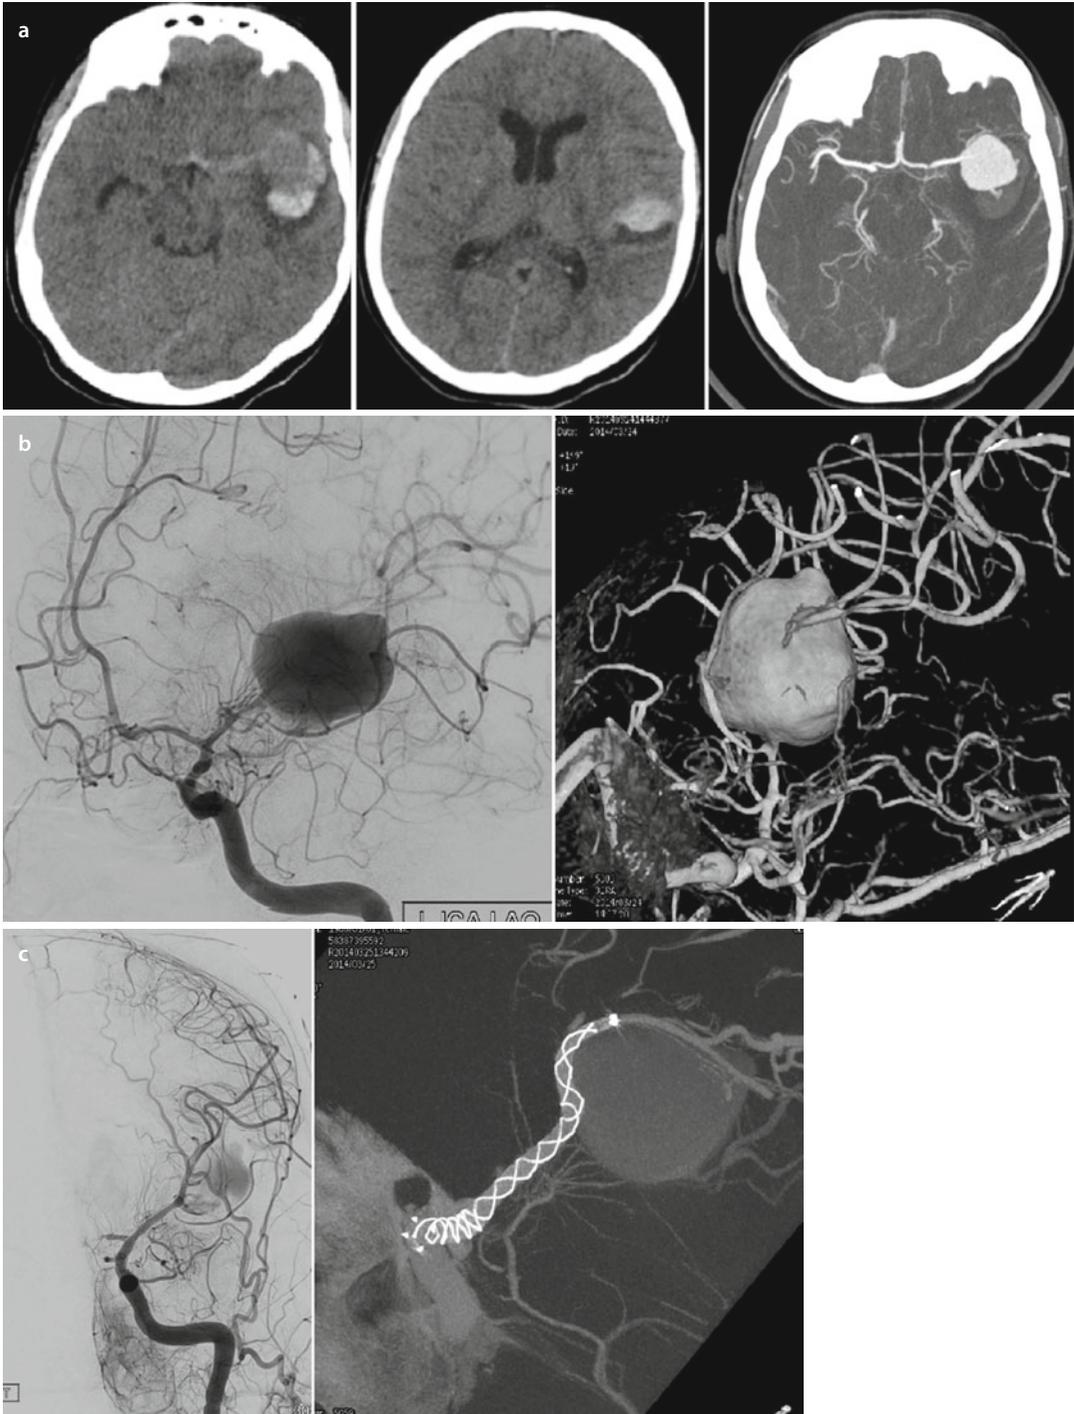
A 34-year-old lady presented with sudden onset severe headache. (a) NECT with CTA reveals a 35 × 25 mm-sized acutely ruptured left MCA partially thrombosed GIA with acute SAH. (b) Cerebral DSA reveals a 27 × 25 mm-sized luminal filling of a MCA bifurcation GIA. The lower trunk of MCA is incorporated into the aneurysm. (c) On March 2014, the aneurysm was treated using FRED® FD across the aneurysm. Immediate postprocedural angiograms reveal significant decrease in aneurysmal filling with good antegrade flow in the upper trunk of MCA. IA VASO® CTA shows the relative position of FD and aneurysm.
